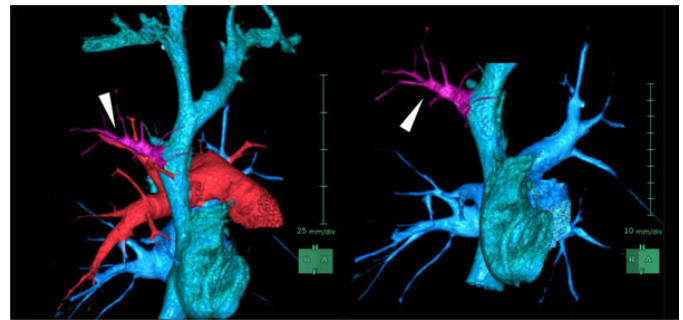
CTA with VR reconstruction showing an aberrant vessel (purple, white arrow head) flowing around the junction of the SVC and the azygos vein.
